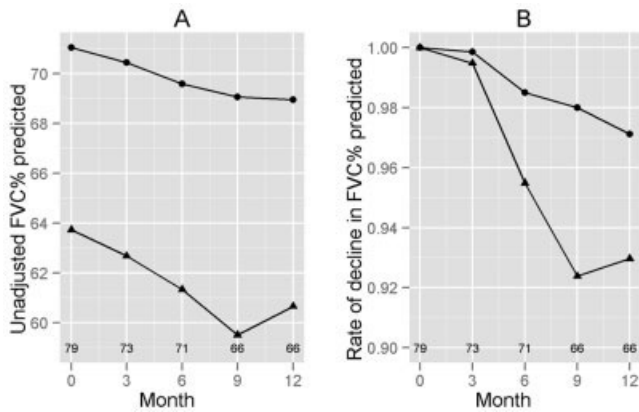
A, Decline in forced vital capacity (FVC) % predicted, according to high-resolution computed tomography–defined maximum fibrosis scores (● = 0–2; ▲ = 3–4). B, Rate of decline in the FVC % predicted adjusted for the baseline FVC % predicted. Values above the x-axis represent the numbers of patients corresponding to the data points for the given months.
